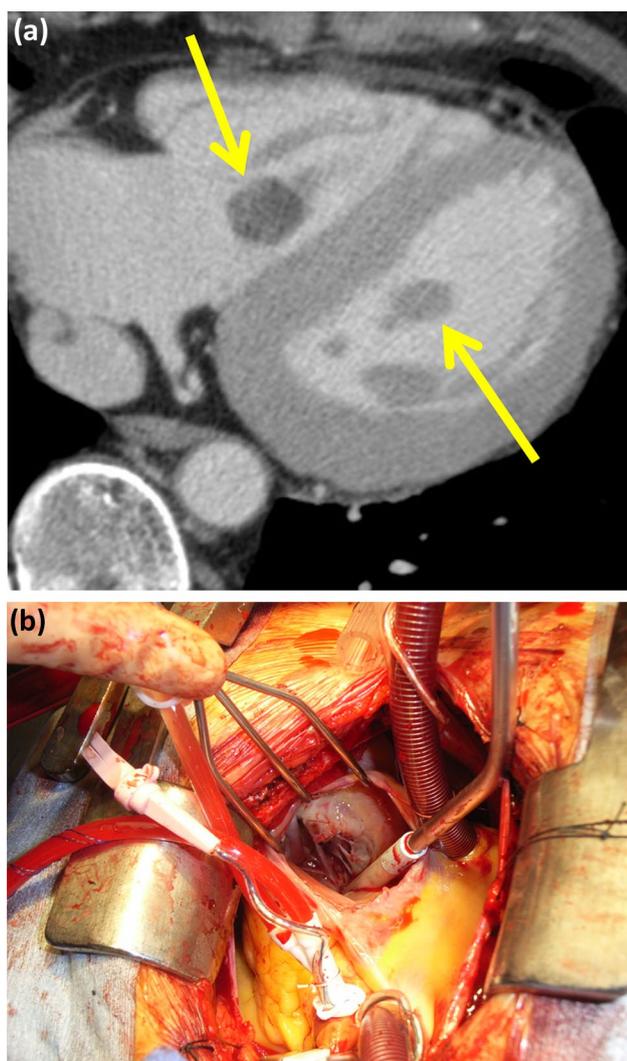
Enhanced computed tomography revealed each tumor originating either left ventricle or right ventricle (a). Operative findings showed jelly-like tumor, which was originating in the right ventricle, adhering tricuspid posterior leaflet (b)
